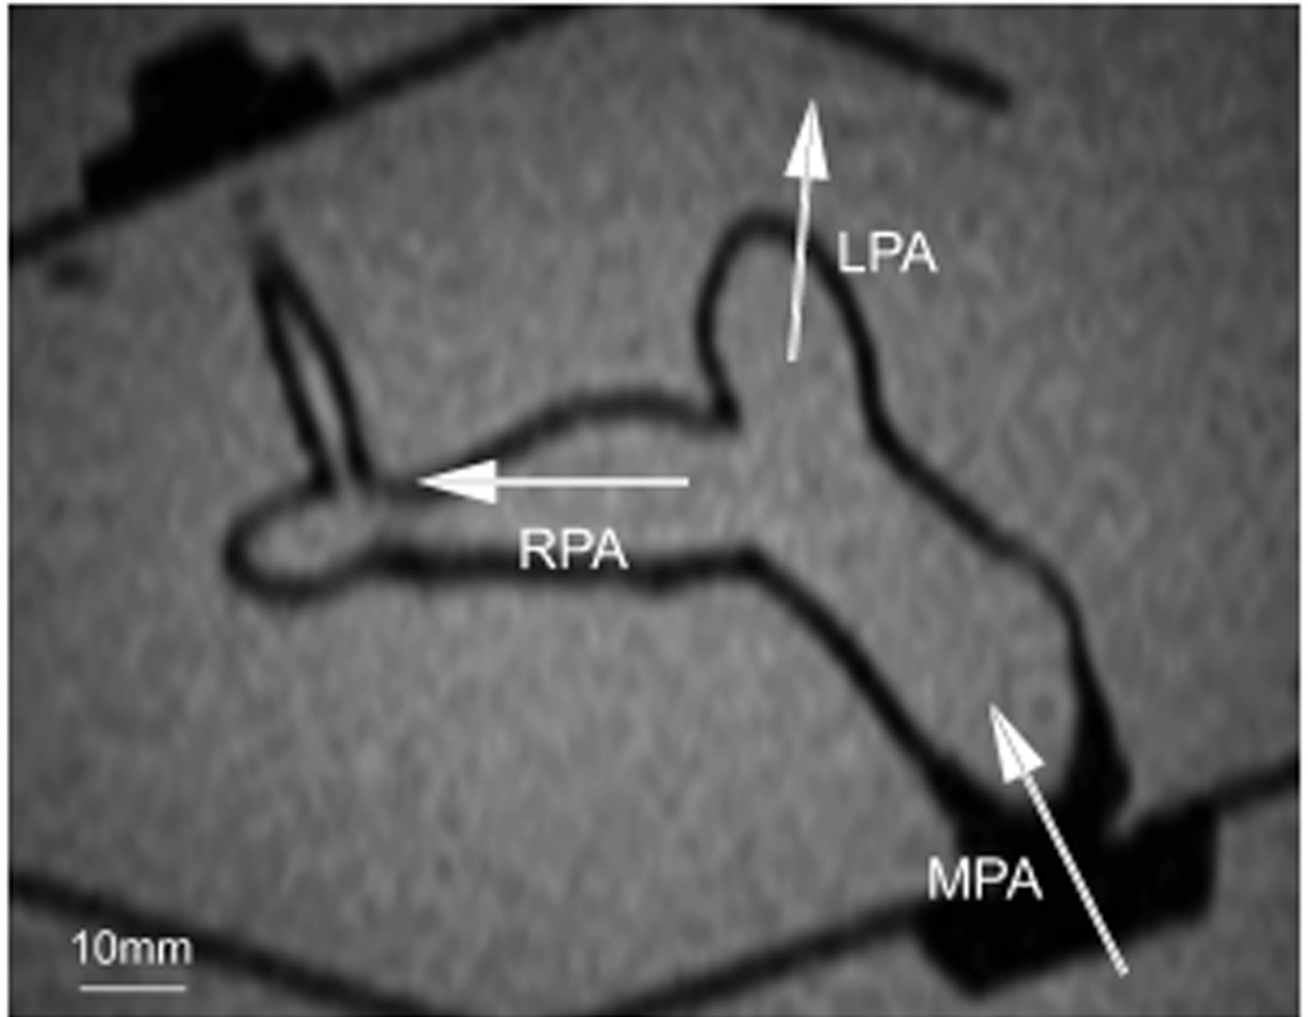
A single slice from an MR image of the pulmonary arterial model submerged in an acrylic tank of water. The image is obtained with a multislice scout sequence. The MPA, RPA, LPA, and surrounding acrylic box are clearly visible. Scale is indicated.
